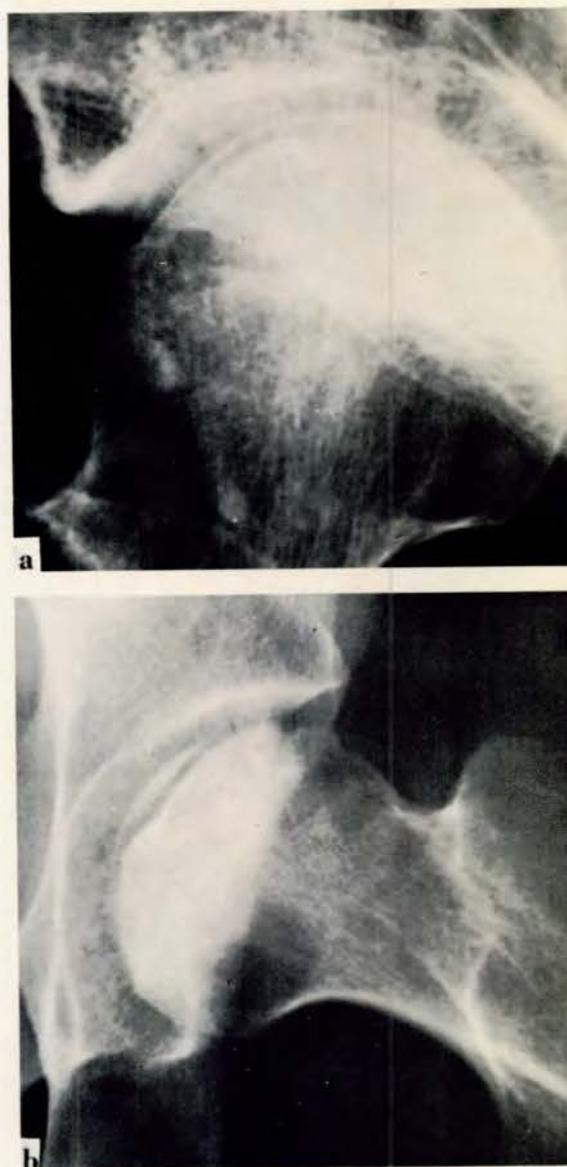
Lateral roentgenograms of hips with early Stage III osteonecrosis lesions: (a) secondary subchondral fracture extending through necrotic bone in anterosuperior quadrant of femoral head in lesion with minimal articular incongruity; (b) another positive radiolucent crescent-line sign (translucent subcortical band sign) with dissection of subchondral bone.
